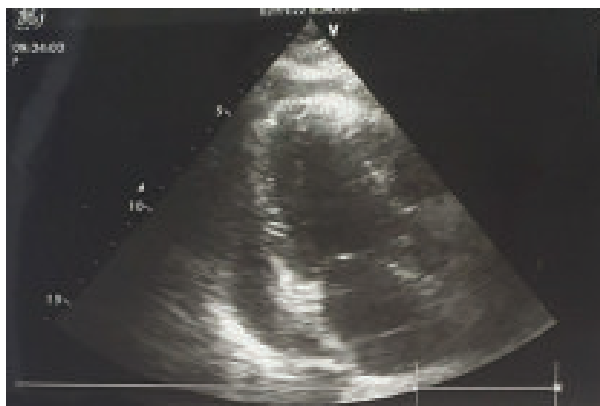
Echocardiography showing severe pericardial effusion at posterior wall (indicated by arrows)
